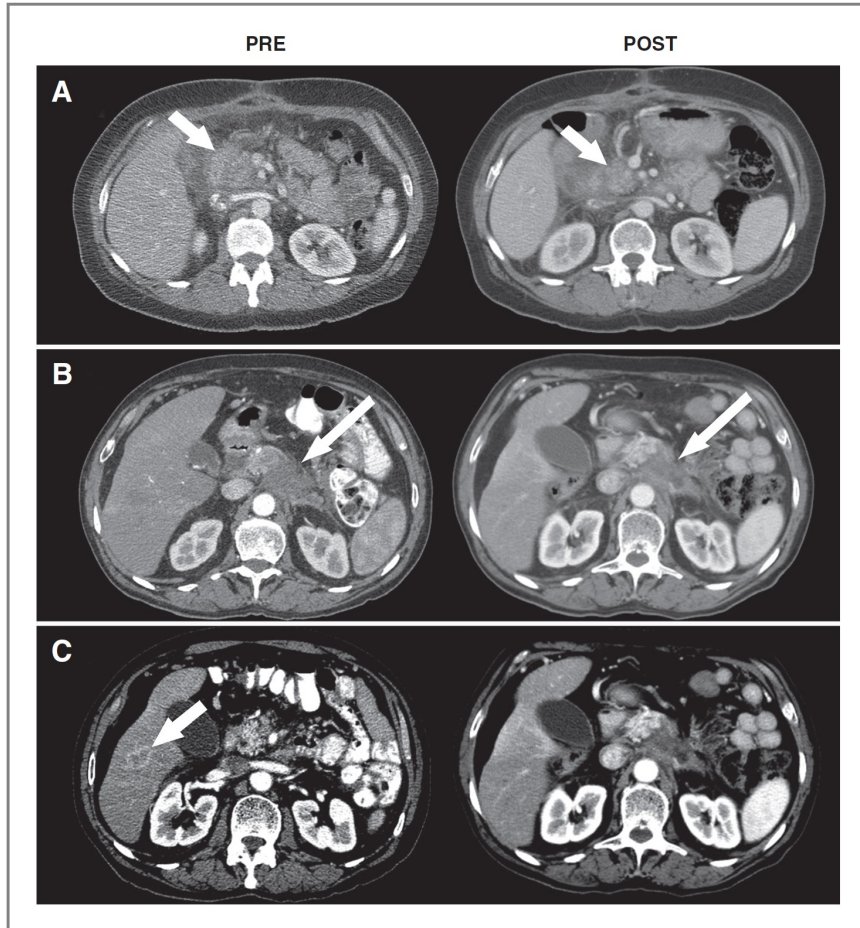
CT image examples before (PRE) and after treatment with ^{90}Y -hPAM4 (POST). A, a 63-year-old female diagnosed 5 months earlier with locally advanced pancreatic cancer was previously treated with gemcitabine and external radiation therapy. At study entry, the patient had a 6.3-cm mass in the head of the pancreas which reduced to 3.0 cm by 4 weeks after ^{90}Y -hPAM4 (arrows). B and C, a 70-year-old male diagnosed 4 months earlier with locally advanced disease received 5-FU and external radiation therapy initially and then gemcitabine. At study entry, the patient had a 4.5-cm mass in the body of the pancreas which reduced to 3.3 cm after treatment with ^{90}Y -hPAM4 (long arrows) and a 2.3-cm lesion in the liver (short arrow) that was no longer measurable.
